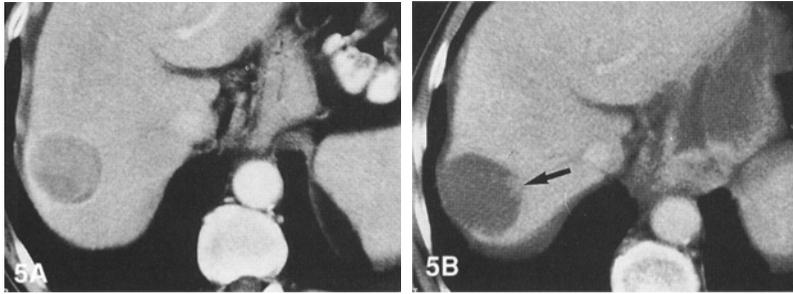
Encapsulated HCC treated with PEI alone: early follow-up with CT. A Contrast-enhanced spiral CT shows a HCC lesion with an enhancing capsule before treatment with 40 ml of ethanol under US guidance in one session. B On the contrast-enhanced spiral CT image the treated lesion remains unenhanced, but a small nodular area of enhancement is seen close to the capsule, corresponding to viable tumor (arrow).
